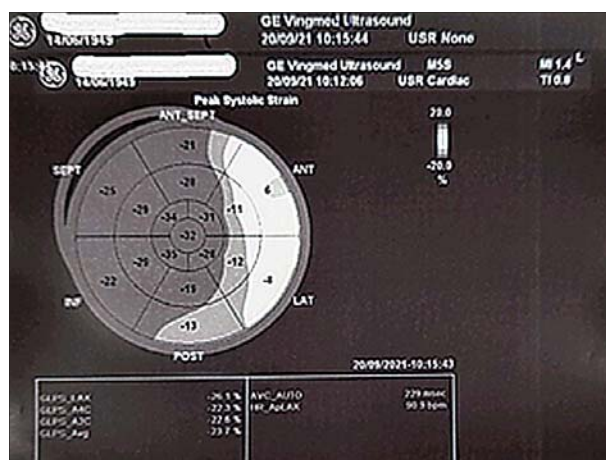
Result of 20 mg dobutamine stress echocardiography
